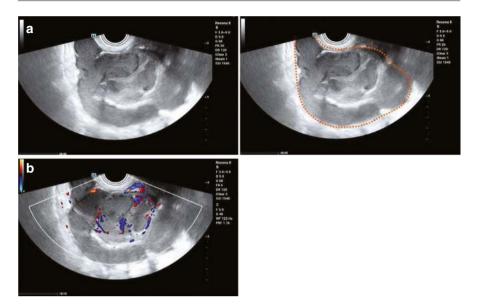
(a) Tubal abscess on B-mode ultrasound showing a tortuous tubular cystic mass with well-defined borders, incomplete septation, poor sonolucency, and dense, fine, punctate echoes. The tubal abscess is circled in orange. (b) Color Doppler ultrasound shows abundant blood flow signals in the incomplete septations
